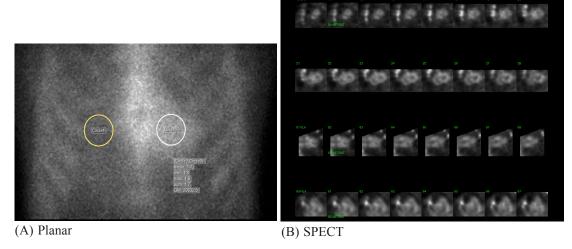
99m-Technetium-pyrophosphate scan. The heart to contra-lateral lung ratio was 1.7 at 1 hour. Semi-quantitative visual grading of cardiac myocardial uptake was grade 3, uptake greater than ribs. (A) Single-photon emission computed tomography (SPECT) imaging revealed significant myocardial uptake of tracer. (B)
